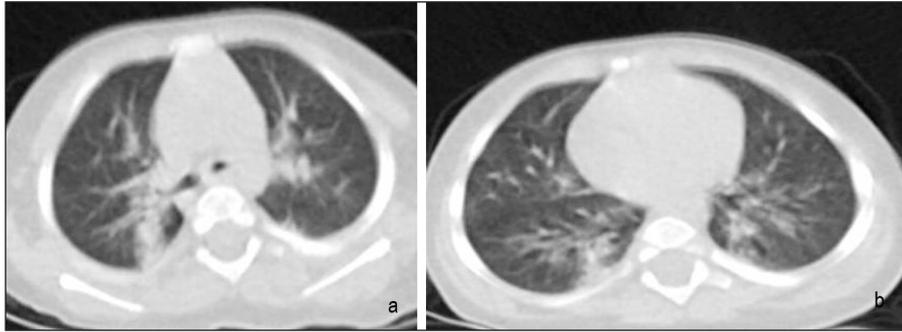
A, B) Chest computed tomography images at presentation, showing bilateral sporadic ground-glass opacities and consolidated areas in the right lung.
